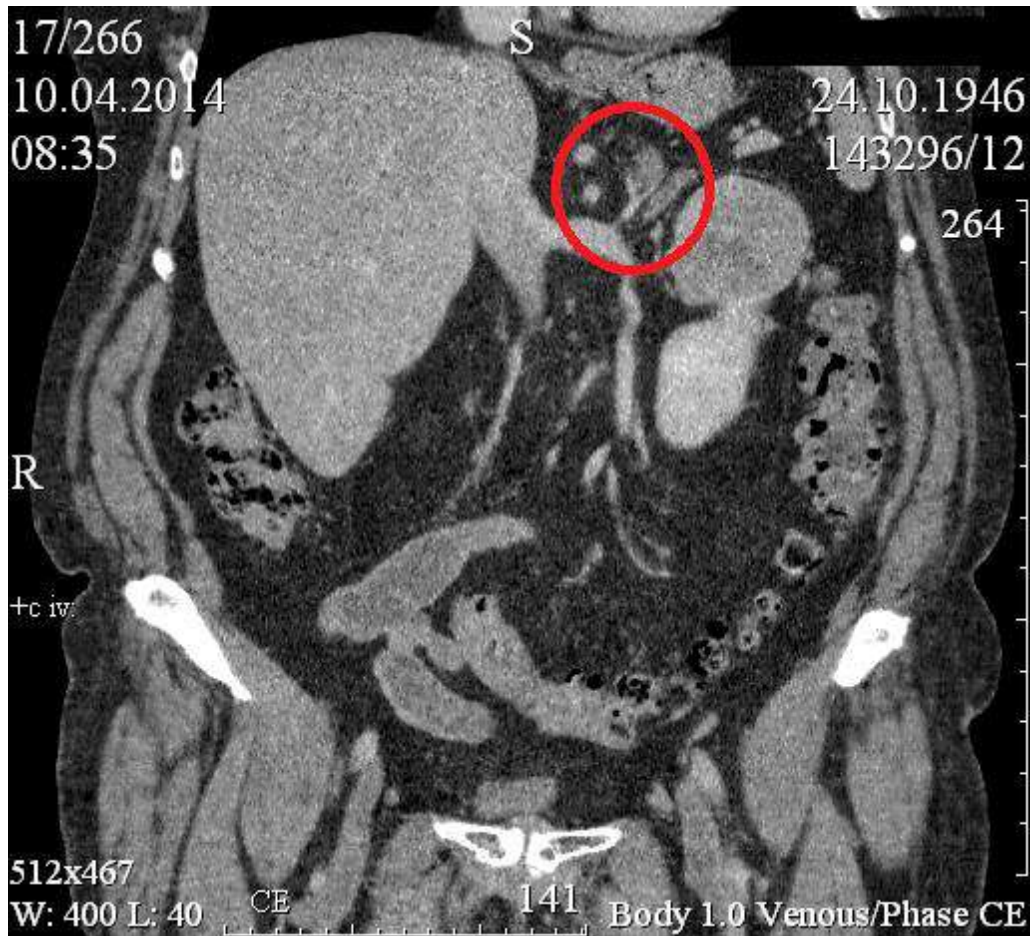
Adenoma of the left adrenal gland, neoplasm of the left kidney. Computed tomography, venous phase of the study.
